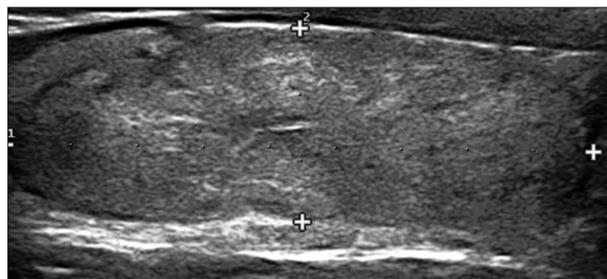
Longitudinal sonogram of the left thyroid from a 65-year-old woman with minimally invasive follicular carcinoma. A hypoechoic solid nodule is shown.
